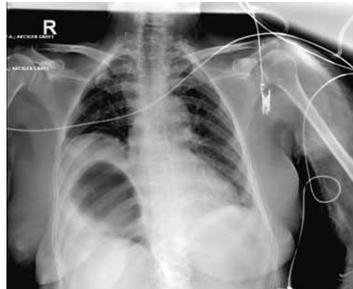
Preoperative chest radiography: Lung atelectasis and bowel loops due to diaphragmatic hernia in the right hemithorax.
